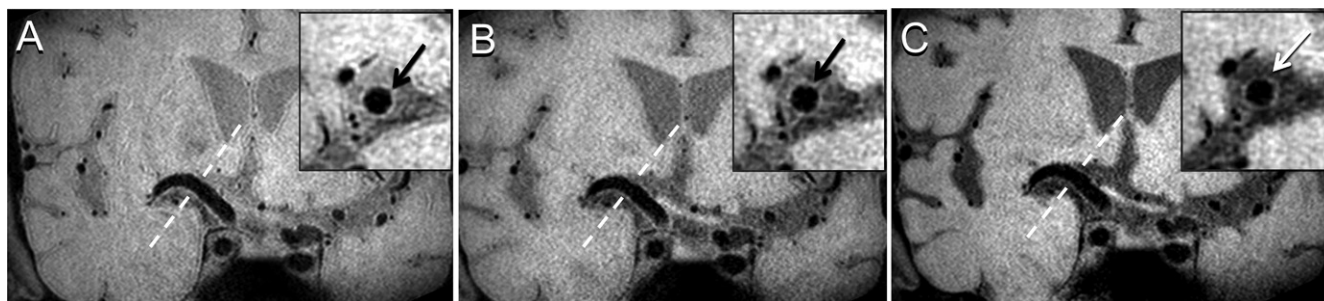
Cerebrospinal fluid (CSF) signal suppression on three-dimensional (3D) vessel wall (VW) MRI scans in a 77-year-old healthy male volunteer. (A) A 3D VW MRI scan (repetition time msec/echo time msec, 2000/37) shows poor contrast between CSF signal and the VW. (B) CSF signal is attenuated by reducing the repetition time to 1000 msec but at the cost of reduced signal of the VW. (C) CSF signal is further suppressed by using an antidual equilibrium post pulse while maintaining the repetition time at 2000 msec to mitigate signal loss of the VW. All images were acquired with the same acquired resolution and scan times.
